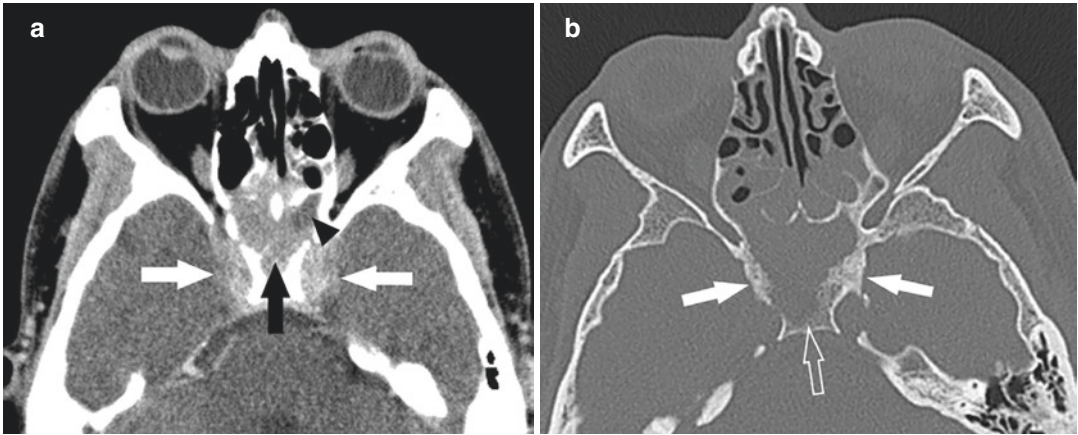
Sinonasal tuberculosis. (a) Axial contrast-enhanced CT image shows an enhancing soft tissue mass in both sphenoid sinuses (black arrow) with hypodense area of necrosis (black arrowhead). The soft tissue extends outside the sphenoid sinus to involve both cavernous sinuses (white arrows). (b) Axial CT image taken in bone
